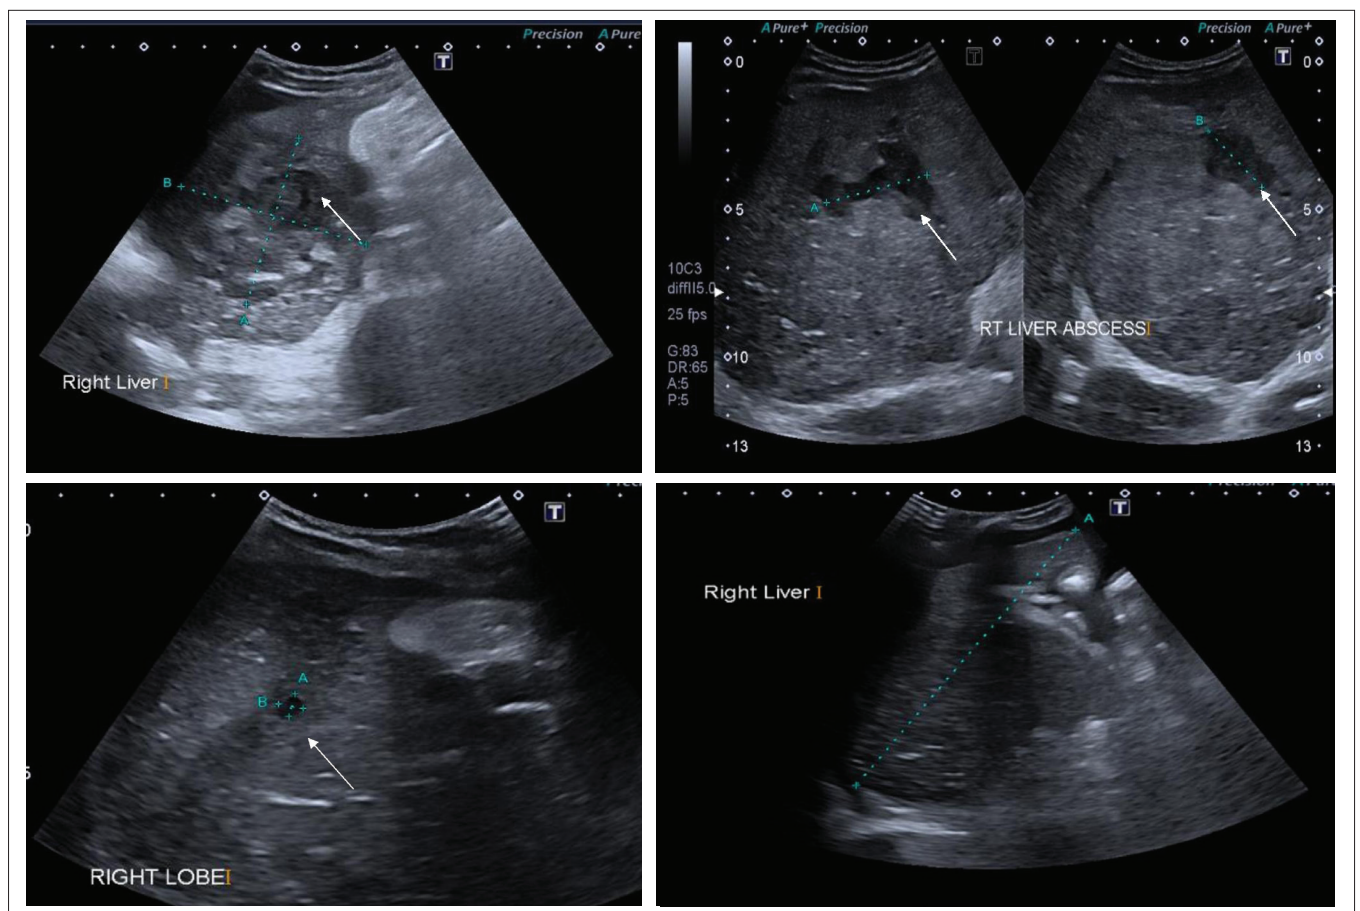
Abdominal ultrasound: Progression of the hepatic abscess (white arrow) (i) initial (60 mm x 64 mm), (ii) 3 weeks later (39 mm x 28 mm), (iii) 1.5 months later (4.8 mm x 4.9 mm) and complete resolution (iv) 3 months later.
